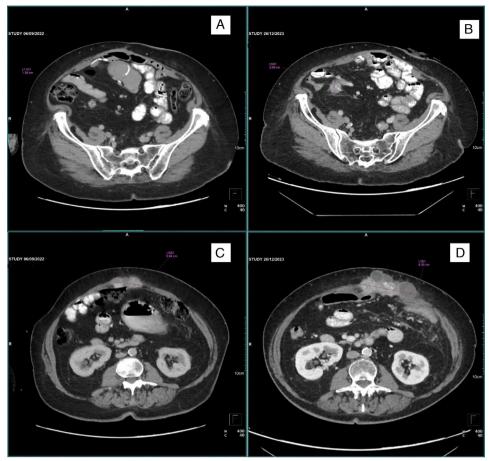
CT scan images. (A) Implant in right iliac fossa in 2022; (B) Implant in right iliac fossa which increased in 2023; (C) Implant in anterior abdominal wall in 2022; (D) Implant in anterior abdominal wall which increased in size in 2023.
